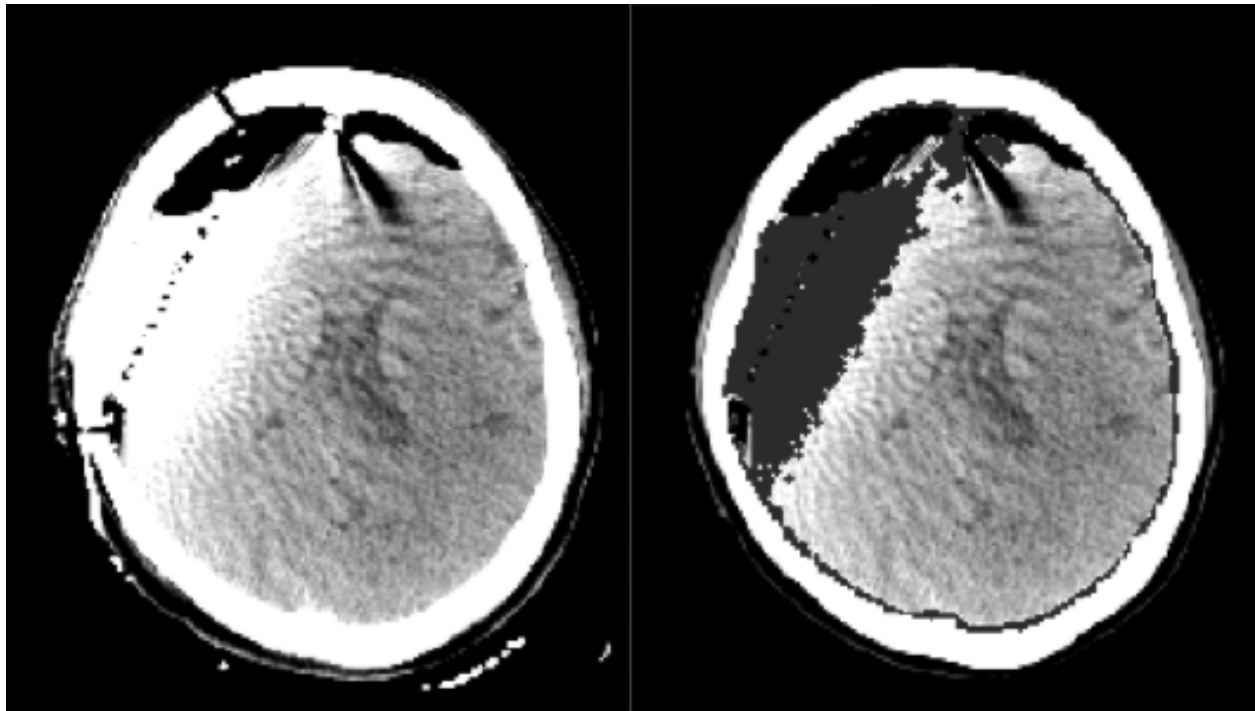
Original post implantation CT on the left and processed image on the right to be used as fixed image in nonrigid registration step
